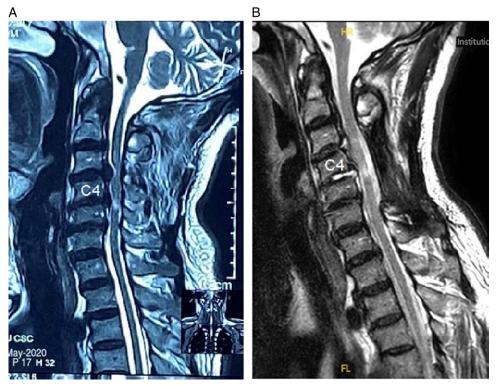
(A): The preoperative saggital MRI in a 65-year-old showed C3–C6 spinal stenosis with intrinsic T2W MR C45cord edema. (B): The postoperative saggital MRI showed the spinal cord completely decompressed following a laminectomy/fusion.
